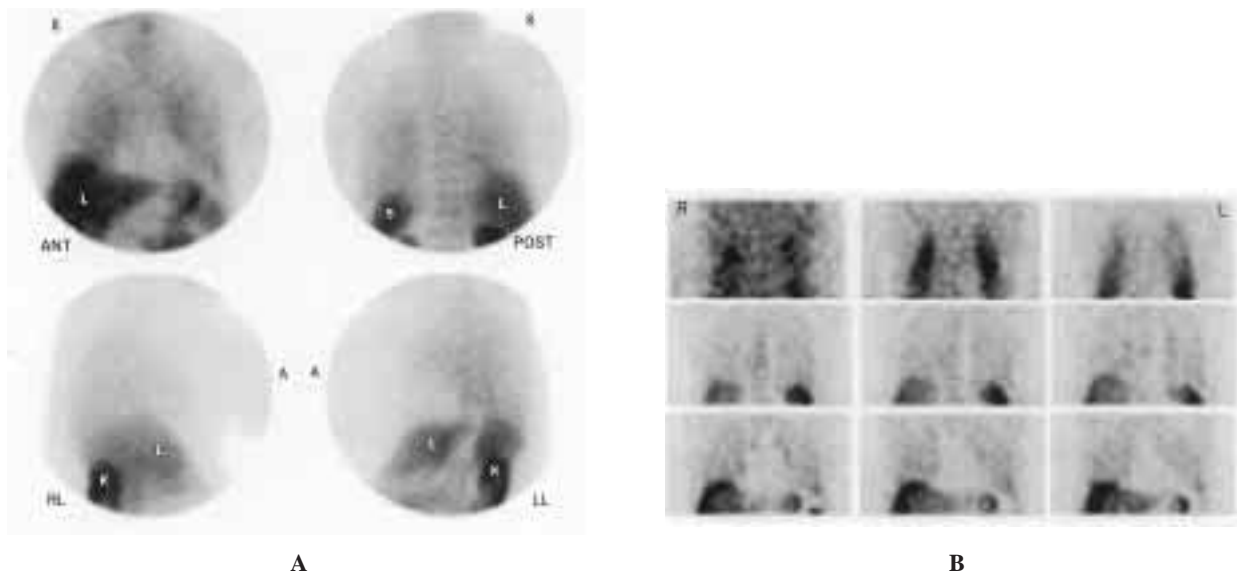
A: (H9242) Mildly and diffusely increased uptake in the lungs on planar images. Anterior (ANT) and posterior (POST) views show mildly and diffusely increased radioactivity in both lungs, which is graded as “+ / + +”, and a prominent cardiac area of photon-deficiency in the anterior projection and thoracic and upper lumbar vertebrae identifiable in the posterior projection; activity in the liver (L), spleen (S), and kidneys (K) is higher than that in the lungs and vertebrae. Left lateral (LL) and right lateral (RL) views show mild and diffuse uptake in the lungs, higher radioactivity in the liver, spleen, and kidneys; renal activity is most prominent. B: Mildly and diffusely increased uptake in the lung on SPECT: Coronal sections from the posterior to the anterior direction: symmetrically and diffusely increased uptake in both lungs, designated as “+ / + +”, is shown in the upper panel; in the bottom panel, there is a photon-deficient area representing the cardiac zone surrounded by the lungs, and upper boarder of the liver.
